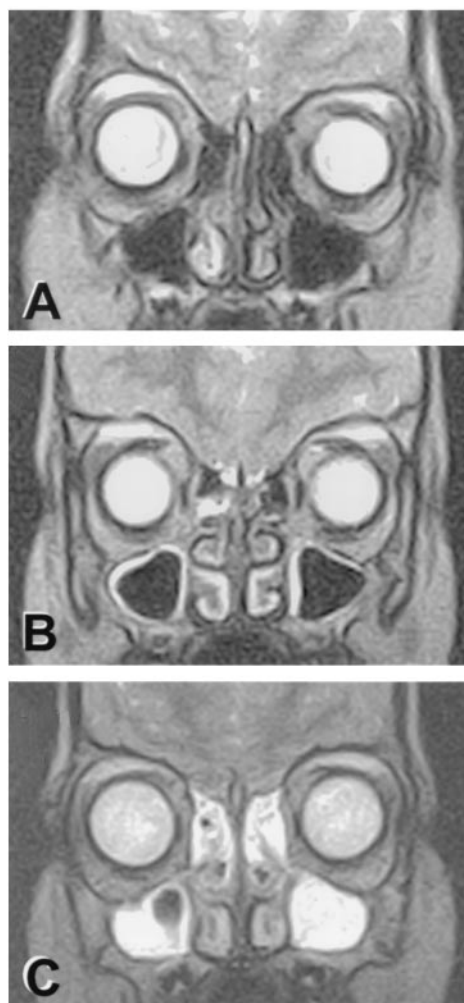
A representative case of normal MRI finding (A), minor abnormality MRI finding (B), and major abnormality MRI finding (C) in a series of 60 children with acute respiratory infection. The increased blood flow in the inferior turbinate on the more congested right side after the nasal cycle is well seen in A as well as the mucosal edema in both maxillary sinuses and right ethmoidal sinus in B and major abnormal changes in ethmoidal and maxillary sinuses in C. The ostial region is not adequately visualized to allow estimation of ostial patency as a result of the sparse slices and that bony structures are not seen on MRI scans.
